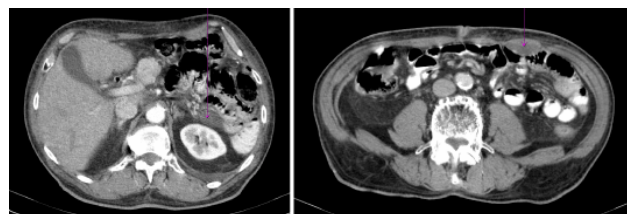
Examen CT: aspect stabil al recidivelor abdominale în cursul tratamentului cu ITK.
